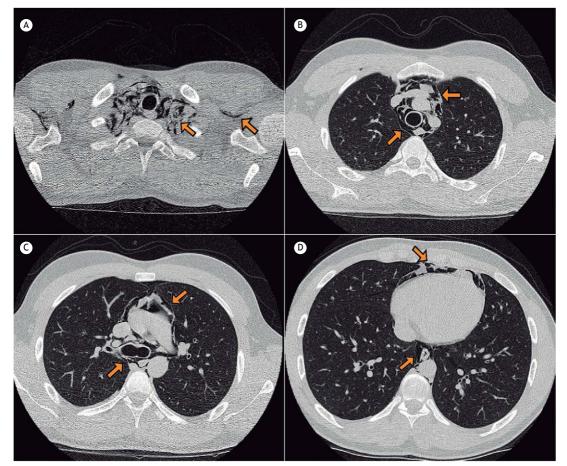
HRCT scans using axial sections, filter and lung window settings, showing the presence of laminar images with marked hypoattenuation representing gas (arrows) in deep topographies in the cervicothoracic transition and axillary regions (in A), as well as in mediastinal, paraesophageal, and paracardiac sites (in B, C and D, respectively).
